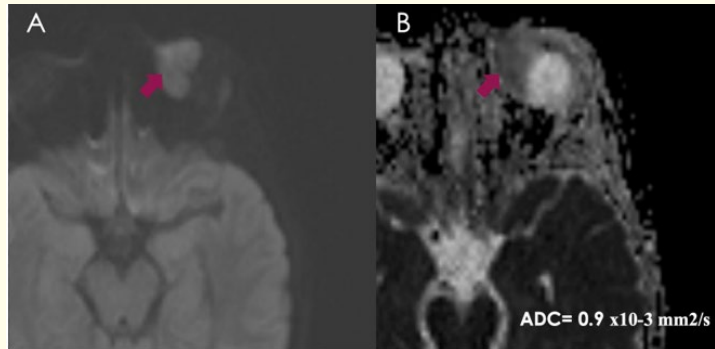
Orbito-cerebral MRI on Diffusion sequence and ADC mapping reveals diffusion restriction, manifested by a diminished apparent diffusion coefficient (ADC) value of $0.9 \times 10^{-3} \text{ mm}^2/\text{sec}$, indicating malignancy.
